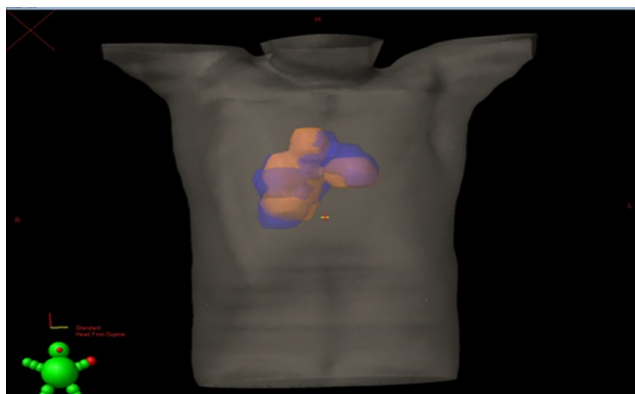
Three dimensional view of PTVs. PTV with blue colour belongs to CT guided delineation. PTV with orange belongs to PET-CT guided delineation. In this patient, PTVpet has a smaller volume than PTVct.
